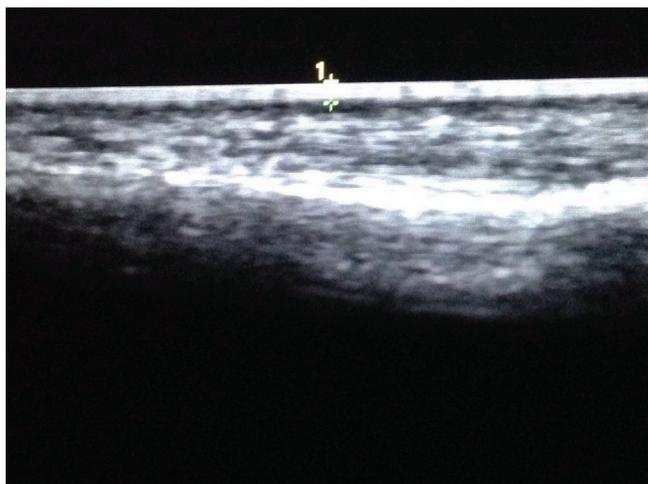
High resolution sonography of skin over dorsum of hand for measuring skin thickness 1 + +: thickness of skin of dorsum of hand
